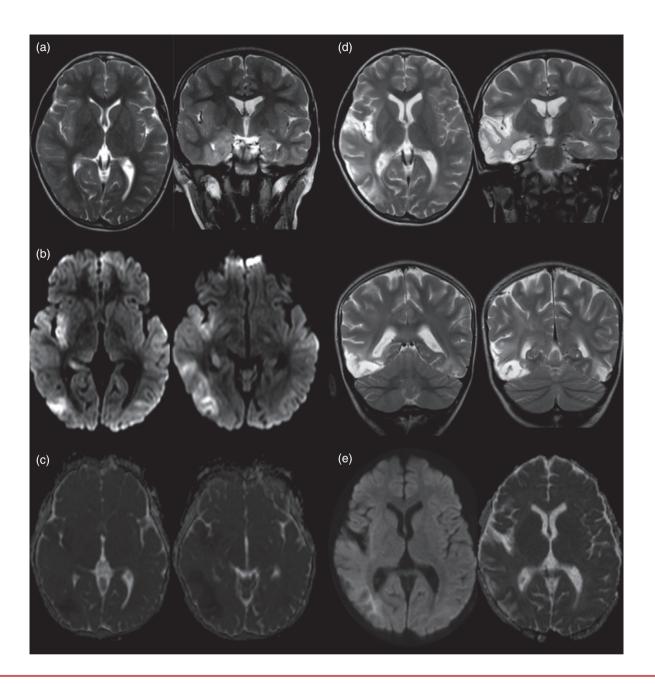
Brain magnetic resonance imaging (MRI) in our paediatric patient with biphasic disease with herpes simplex encephalitis (HSE) followed by herpes simplex virus (HSV)-induced anti-*N*-methyl-p-aspartate receptor (NMDAR) encephalitis. (a–c) Brain MRI 4 days after onset of HSE. (a) T2-weighted axial and coronal images; (b) diffusion-weighted images, axial; (c) apparent diffusion coefficient images, axial. The brain MRI at day 4 from onset of HSE demonstrated diffusion restriction in cortical–subcortical regions in the right temporal lobe, in the right insula, and the right parieto-occipital region. T2-weighted images also showed cortical thickening of the right temporomesial lobe with increased intensity of right parieto-occipital areas. A smaller area of increased intensity was shown in left temporoparietal cortex. (d, e) Brain MRI 4 days after onset of anti-NMDAR encephalitis (33 days from onset of HSE). (d) T2-weighted axial and coronal images; (e) diffusion-weighted images and apparent diffusion coefficient axial images. The brain MRI at day 4 from onset of anti-NMDAR encephalitis showed high signal in right temporal subcortical white matter, atrophic evolution of the known right parietal–insular–temporal lesion, ex vacuo dilatation of the temporal horn of the right ventricle, and small atrophic–degenerative cortical–subcortical areas in the left inferior and mesial temporal gyri. No cytotoxic oedema and no enhancement after gadolinium were observed.
